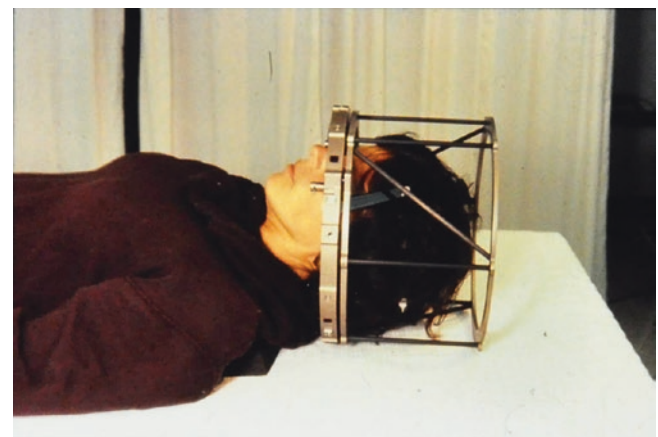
Radionics BRW CT guided biopsy system adopted for SRS frames later. (Courtesy of Dr. Wendell Lutz, Tucson, AZ, USA)
